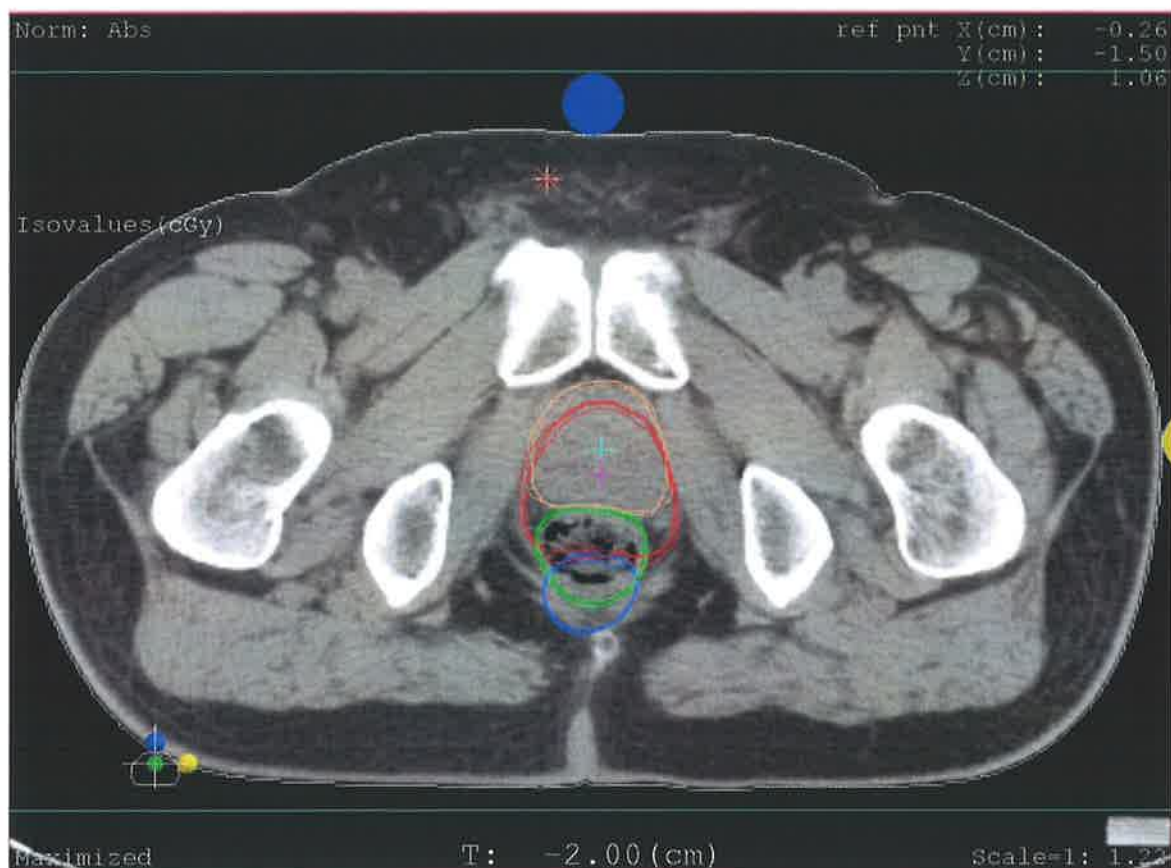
Example of CT slice with contours from both the TPCT and the 2nd CT outlined multiple times
